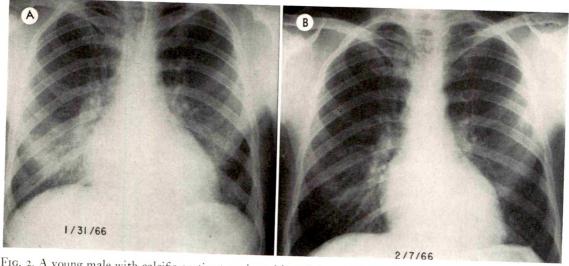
A young male with calcific aortic stenosis and insufficiency. The patient was mildly dyspneic but no physical findings were present in the chest. (A) The admission roentgenogram shows diffuse perihilar haze without other roentgen findings of interstitial pulmonary edema. (B) A roentgenogram made after digitalization shows complete clearing of the perihilar haze. Comment. This case emphasizes hilar haze as a manifestation of interstitial pulmonary edema.
